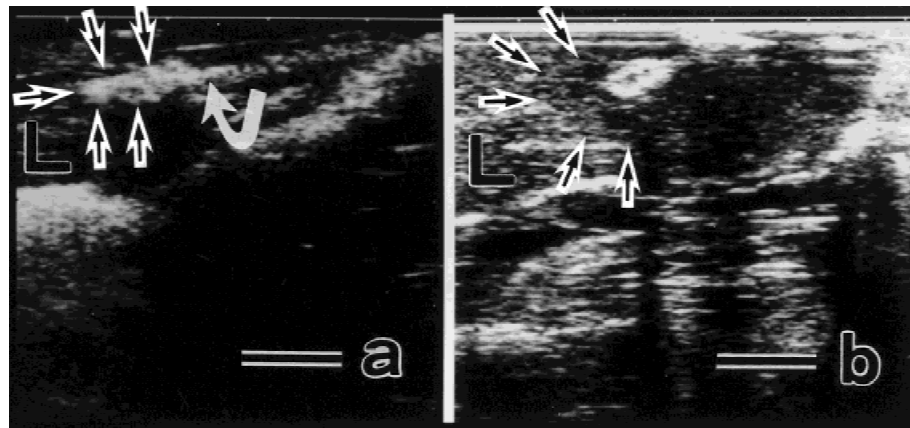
Ultrasound findings. (a) During and immediately after laser ablation, an elliptical hyperechoic area (straight arrows) with a surrounding thin hypoechoic rim was observed around the tip of the laser (curved arrow). (b) At 24 h after laser ablation, the central hyperechoic areas became smaller, whereas the outer hypoechoic zone became wider (arrows). L, Liver. Scale bars = 10 mm.
